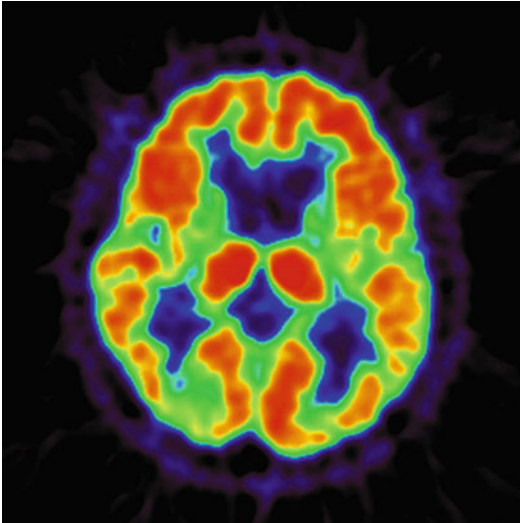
^{18}F -FDG PET images of HD. ^{18}F -FDG PET shows striatal hypometabolism
